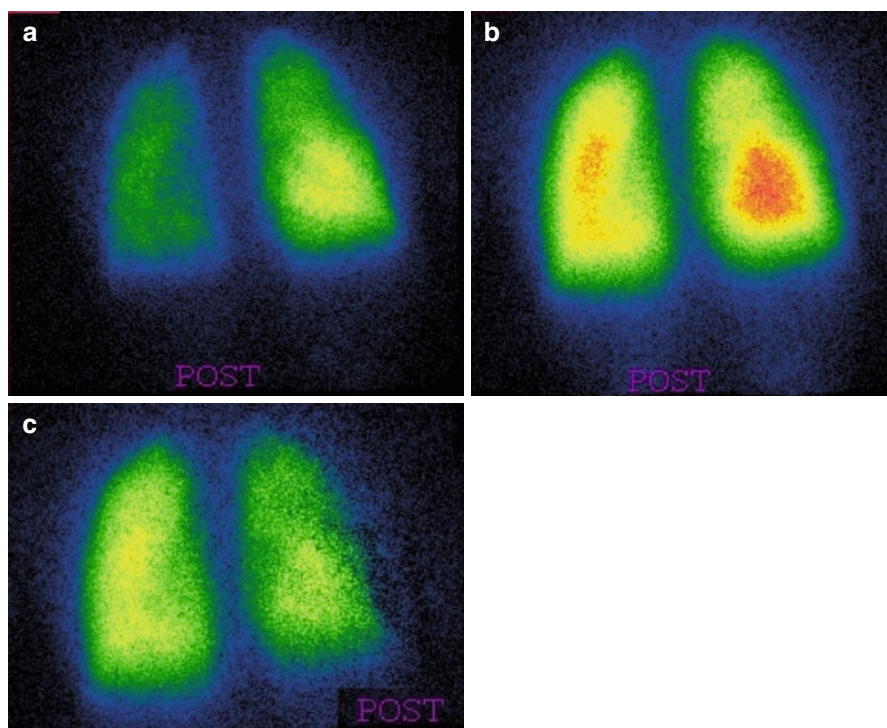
(a) Female, 4 years. Fontan circulation (SVC and IVC anastomized to the pulmonary arteries). MAA pulmonary perfusion scintigraphy (split-dose) after injection in the upper limb: preferential distribution from SVC. (b) After injection in the lower limb, the lung perfusion is symmetric. (c) Subtraction image (summed injections – upper limb injection) showing the preferential contribution from the IVC to the left lung
